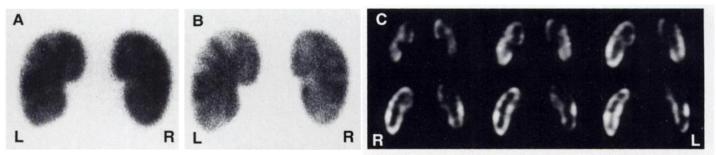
Bilateral multifocal pyelonephritis demonstrated on both pinhole and SPECT images. (A) Planar image using parallel-hole collimation shows multiple areas of decreased ^{99m}Tc-DMSA uptake along the lateral aspect and in the lower pole of the left kidney. There is also a suggestion of a small lesion in the lateral aspect of the right kidney. (B) Magnified posterior pinhole images of the kidneys clearly show multiple lesions in both kidneys. (C) Coronal SPECT images demonstrate bilateral lesions.
